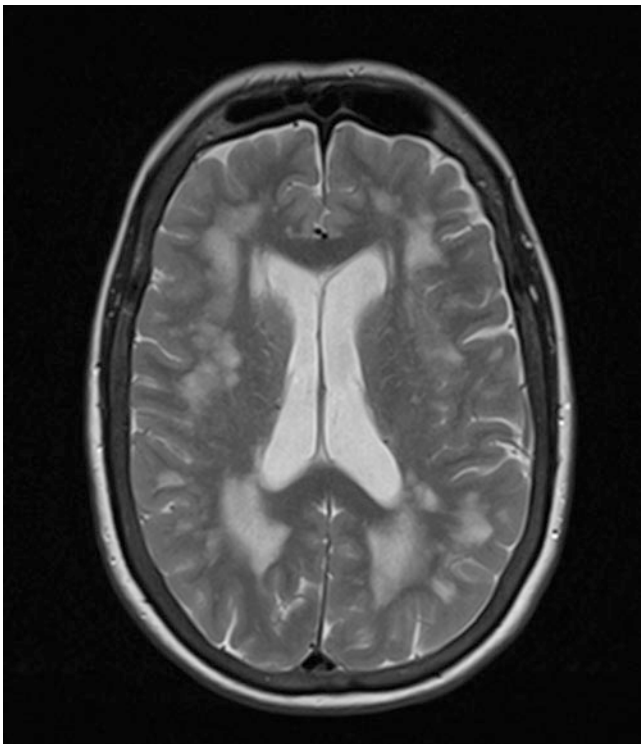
White matter abnormalities on magnetic resonance imaging T2-weighted sequence in a patient with gluten encephalopathy (headache, “foggy brain,” cognitive difficulties). All symptoms resolved with strict adherence to a gluten-free diet. The MRI changes did not resolve but did not progress either
